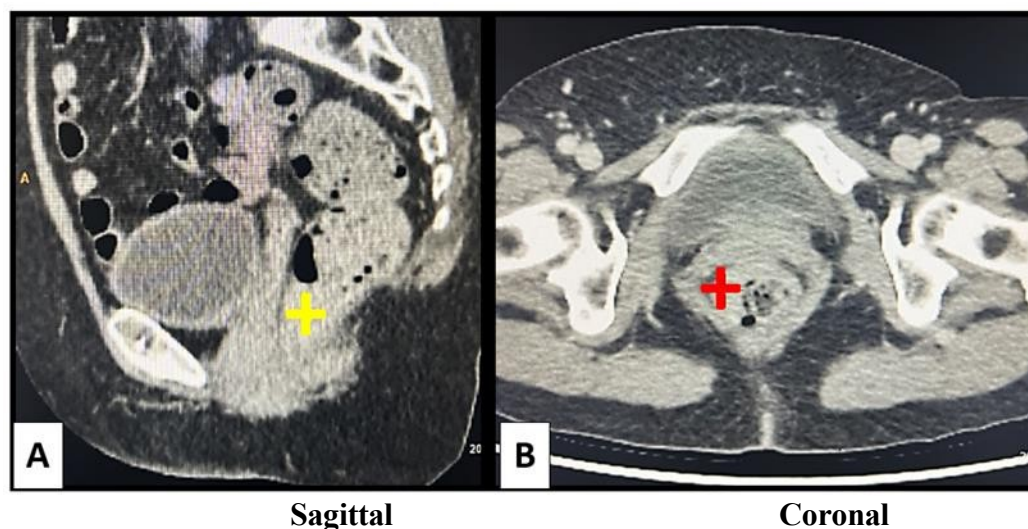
CT scan of the whole abdomen with contrast showing a suspicious mass (cross) at the distal rectum extending to the anorectal region.
